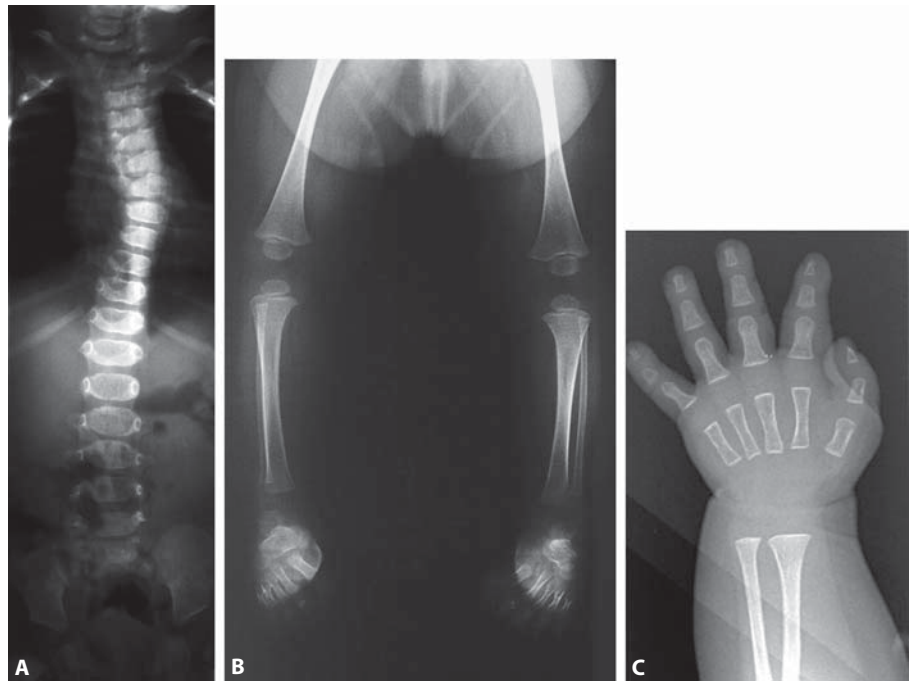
X-rays of the patient at the age 20 months. A The chest showed severe scoliosis. B Lower extremities of the patient exhibited no signs of campomelia. C Shortening of the thumb is striking.
